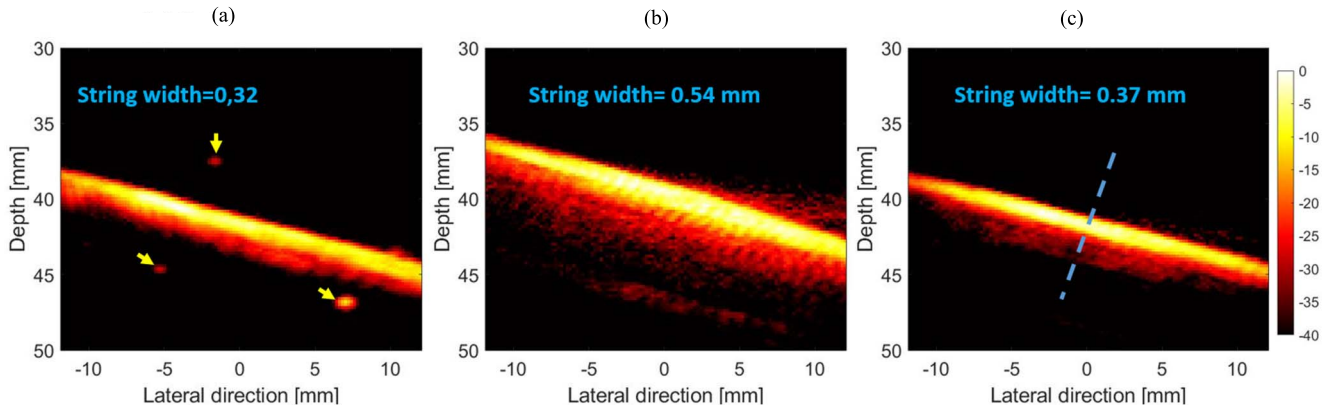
Power Doppler images using the experimental dataset generated (a) without and (b) and (c) with the Sawbones plate in front of the probe [see Fig. 3(c)]. The yellow arrows in (a) show bubbles floating in the water tank. The blue dashed line shows the line (normal to the string) used to calculate the width of the string. The reference image was generated without an aberrator in front of the probe.
